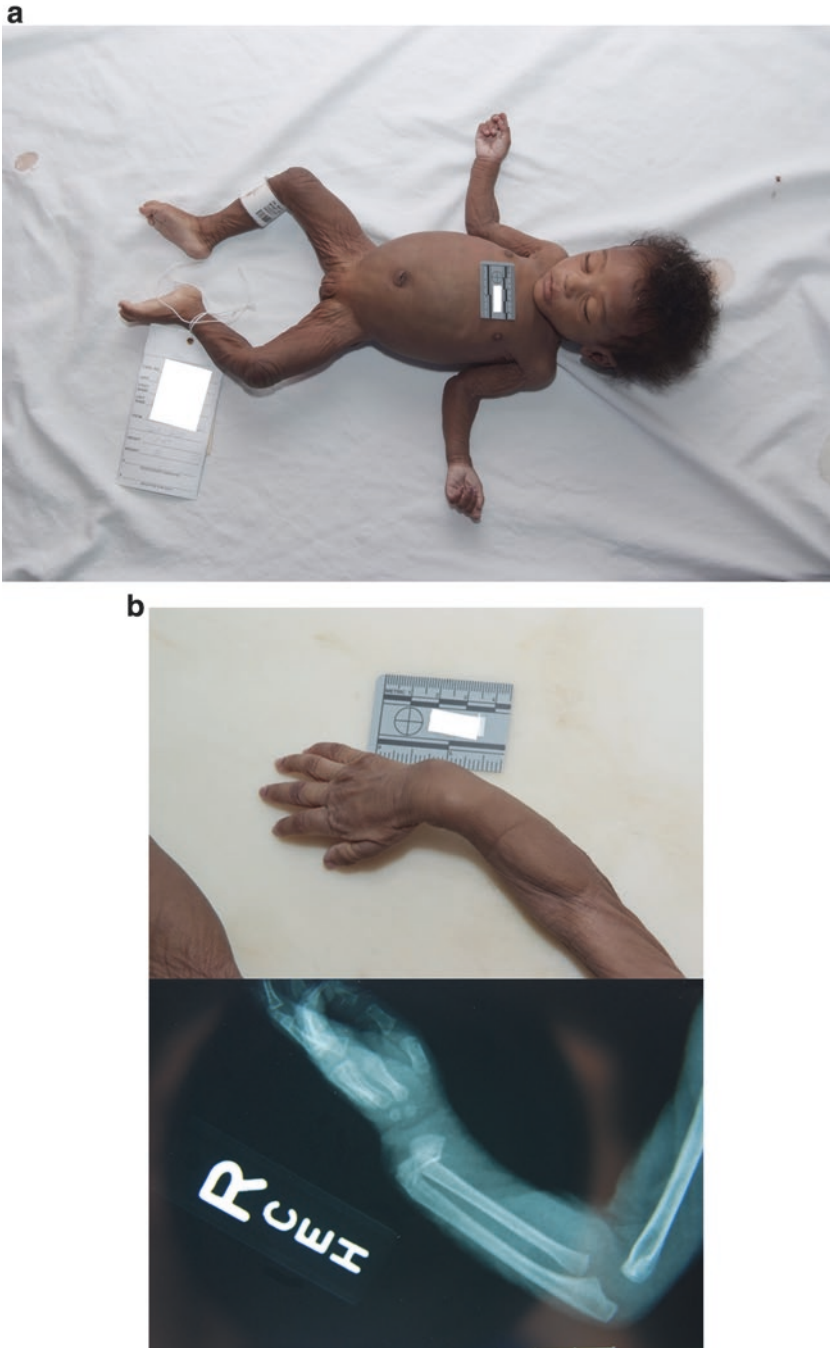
(a) This infant was starved and beaten. Multiple physical signs of malnutrition and dehydration are evident, including her muscle wasting, bloated abdomen, and decreased skin turgor. (b) The malnourished child in (a) had a wrist deformity (top panel) and fracture on radiograph (bottom panel). This fracture could not have happened accidentally in this infant, given her developmental abilities, without a clear account of significant accidental trauma
